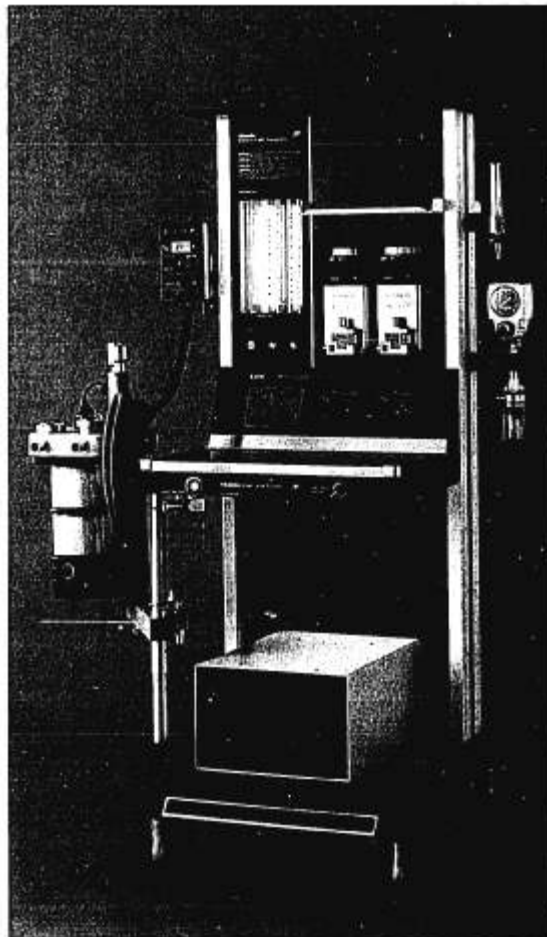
Commercially available, MRI-compatible Ohmeda® Excel 210 anesthesia machine.
